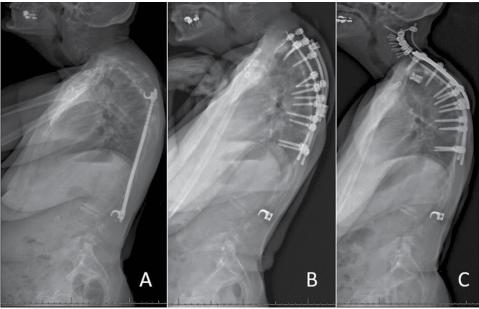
A) Baseline, B) 6 month postoperative following 1st surgery (T4 PSO) and C) 2 year f/u radiographs following 2nd surgery (T2 VCR) of a patient with a cervicothoracic deformity that suffered recurrent upper thoracic PJK. The definitive realignment required extension of the fusion to the upper cervical spine.
